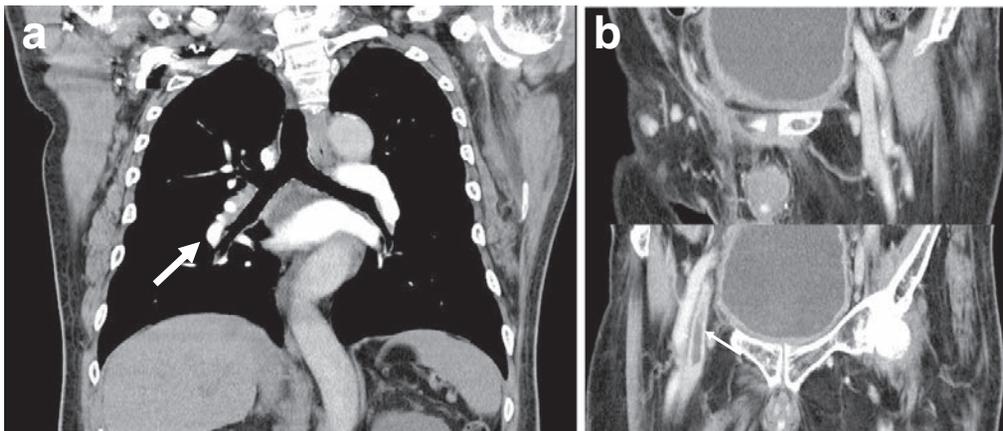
(a, b) On the 15th day of the patient's hospitalization, contrast-enhanced computed tomography showed that most thrombi (the bilateral intrapelvic veins; *small arrow*, the right pulmonary vein; *large arrow*) had resolved.
